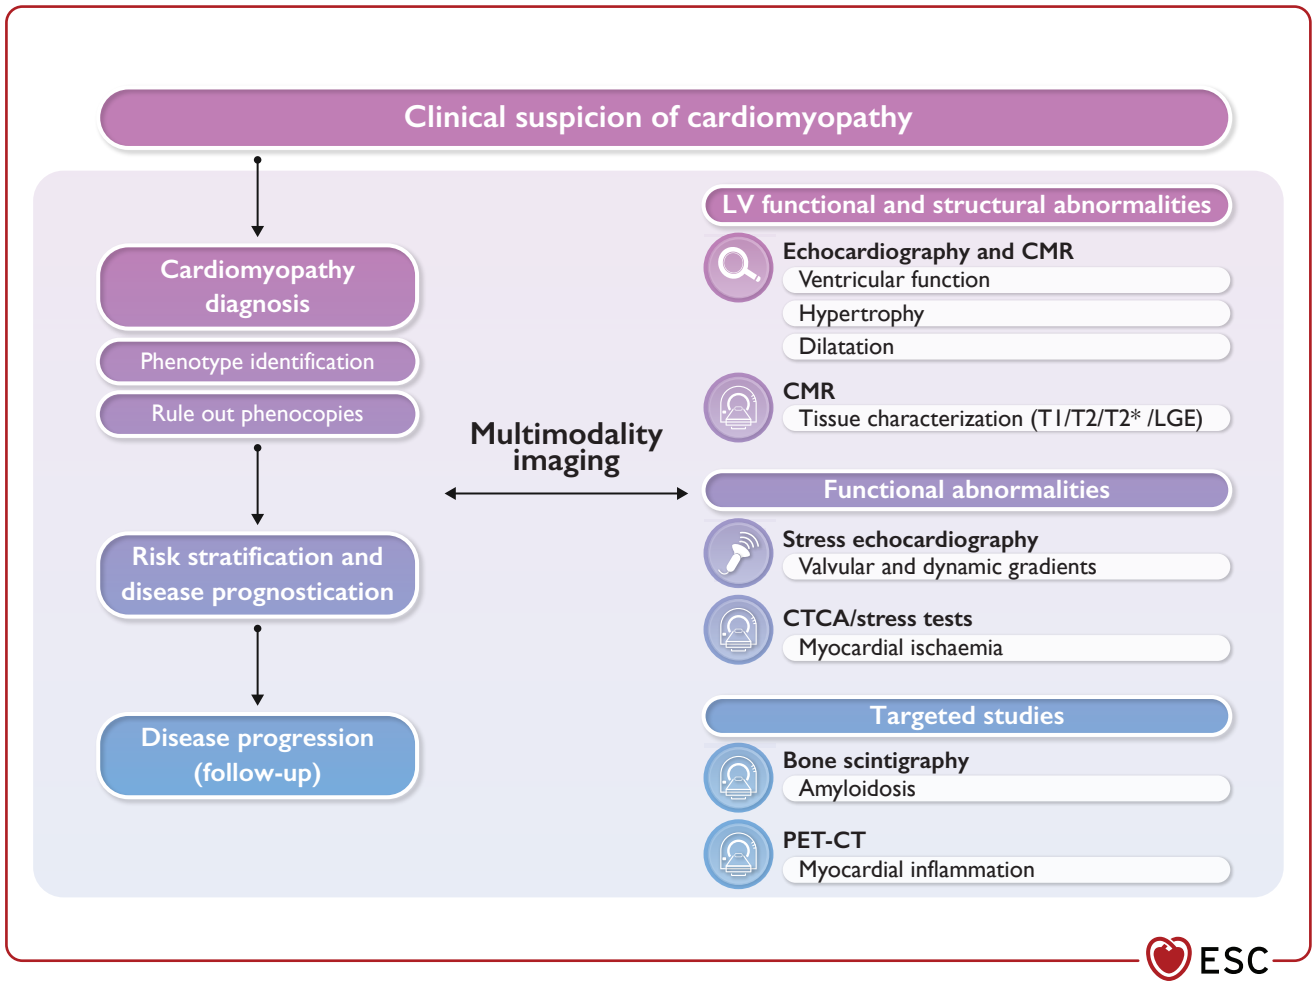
Multimodality imaging process in cardiomyopathies. CMR, cardiac magnetic resonance; CTCA, computed tomography coronary angiography; LGE, late gadolinium enhancement; LV, left ventricular; PET, positron emission tomography.
